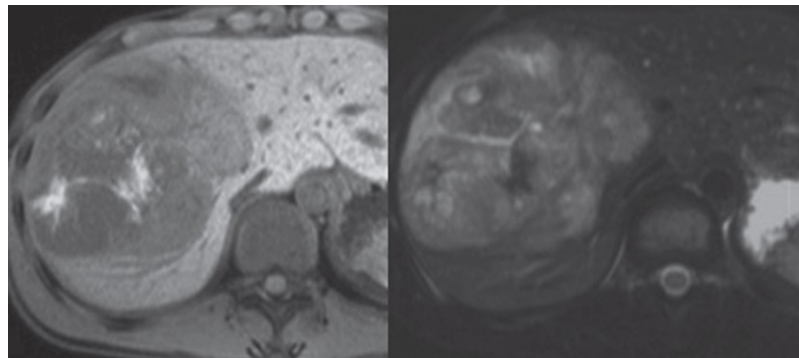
MRI. T1-weighted image demonstrates an inhomogeneous hypointense mass with a more hypointense central scar. On the T2-weighted image the mass shows inhomogeneous hyperintensity and the scar remains hypointense
